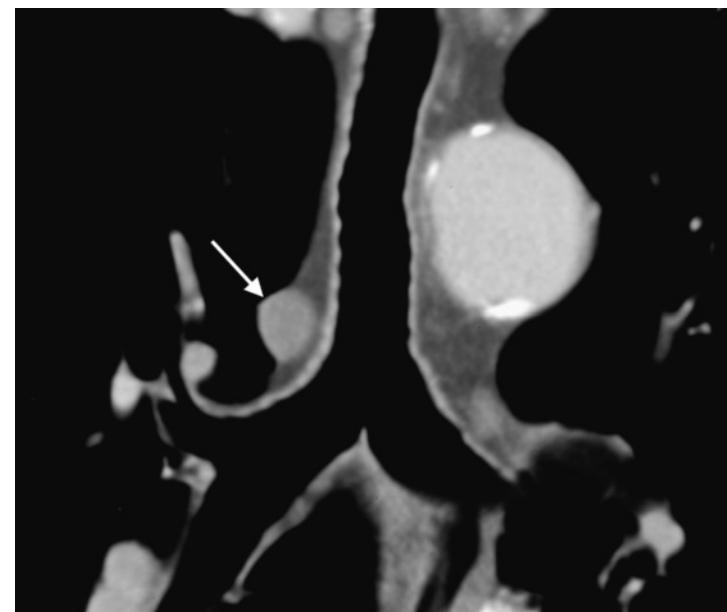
Position of the azygos vein. CT reconstruction of the azygos vein (white arrow) in the coronal projection.
